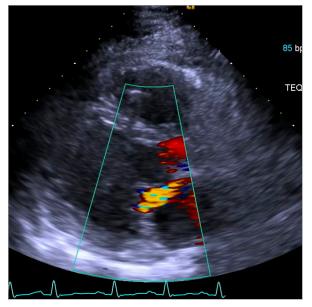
A preoperative transthoracic echocardiogram with Doppler shows severe mitral regurgitation and left ventricular dysfunction.
